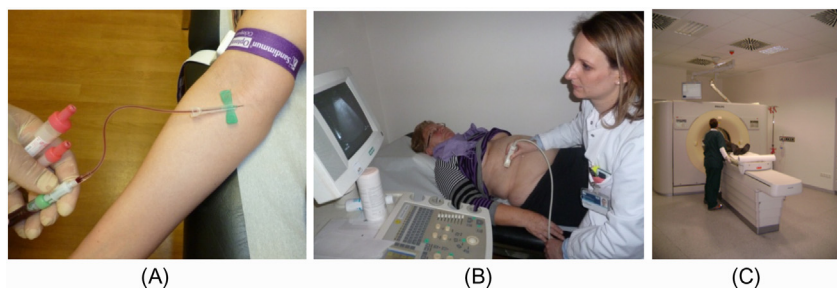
Preoperative diagnostic workup: (A) peripheral or central venous line to take blood samples and for intravenous infusion of fluids and drugs; (B) ultrasonography; (C) emergency CT-scan. *All from MITI.*
